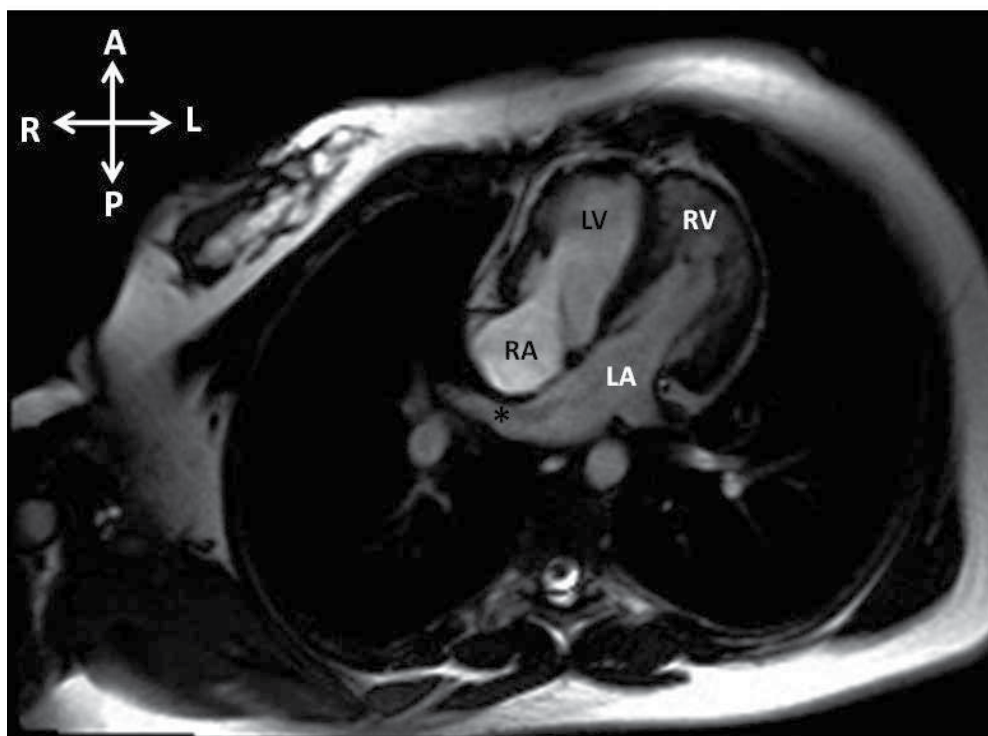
Oblique cut T2-weighted MRI image of 4-chamber cardiac view of ccTGA patient with levocardia. The RA empties into a right-sided, smooth-walled, morphologic LV. A star (*) labels the entrance of a right pulmonary vein into the left atrium, which empties into a trabeculated, left-sided, morphologic RV. RA, right atrium; LV, left ventricle; LA, left atrium; RV, right ventricle.
